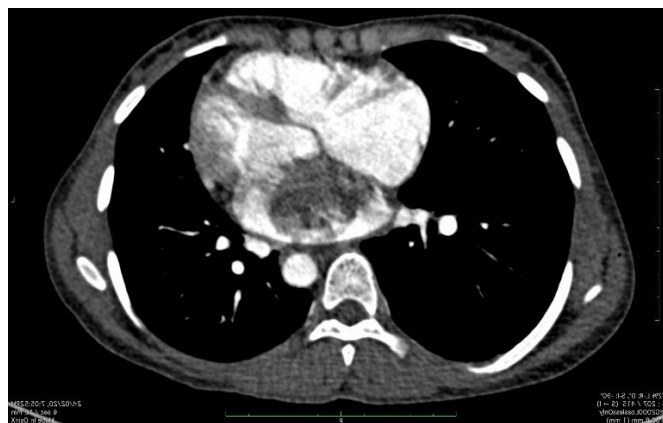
Axial contrast enhanced CT image in four chamber view showing mildly enhancing ill defined hypodense lesion in left atrium
